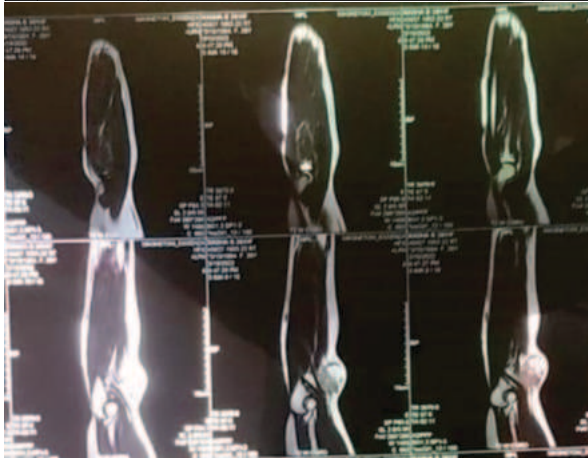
MRI of right forearm
